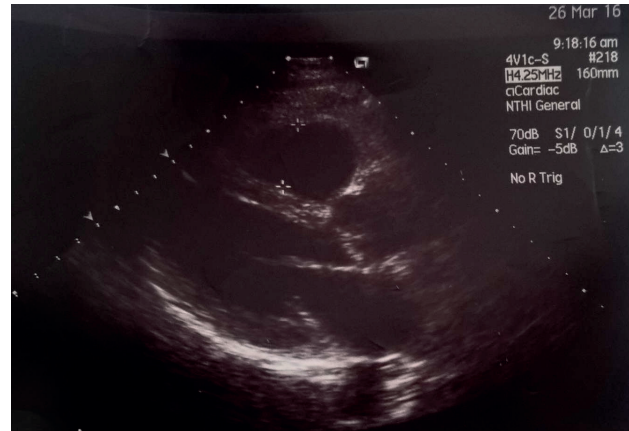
Transthoracic echocardiography (TTE) – Long axis view, where there are no signs of pericardial effusion
